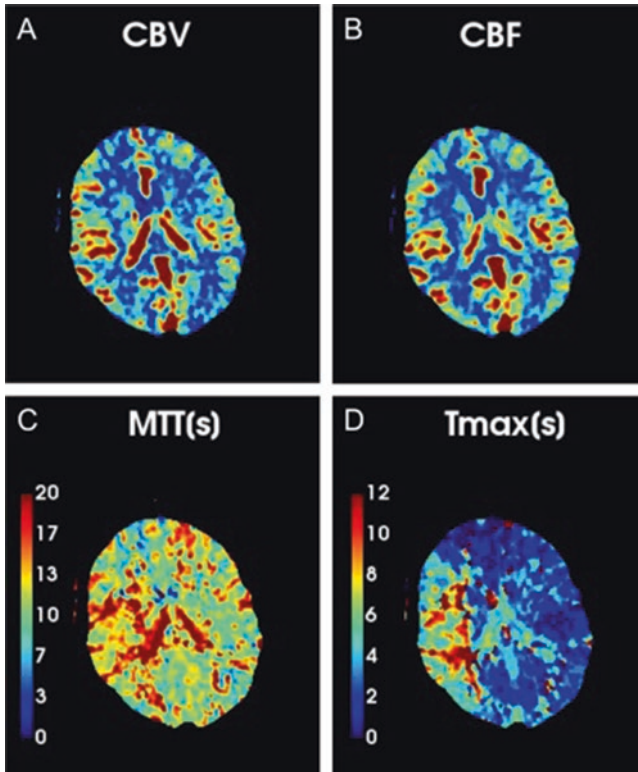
Example of a CT perfusion study demonstrating a right hemispheric area of hypoperfusion related to a right middle cerebral artery occlusion in the M1 segment. Cerebral blood volume (CBV, a) and flow (CBF, b) are preserved, and indicate absence of a significant ischemic core. Mean transit time (MTT, c) and time to maximum of the residue function (T_{\max} , d) are increased in the area of hypoperfusion due to the arterial occlusion
